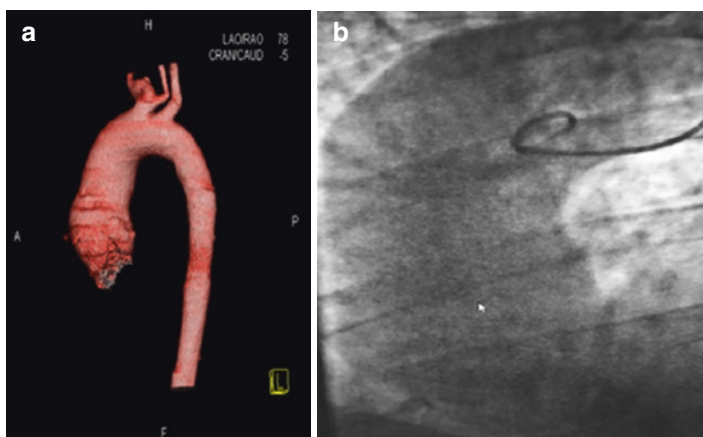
(a) CT angiography of the thoracic aorta, showing an aortic aneurysm. (b) Ascending aortic aortography also showing an aortic aneurysm
